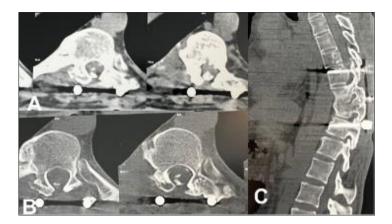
Axial (A and B) and Sagittal (C) CT-scan of the thoracic spine, performed 3 years after surgery, showing intradural, epidural, and periarticular ossifications extending from T8 to T10. Post-traumatic arachnoiditis ossificans of the thoracic spine in 32-year-old man.
